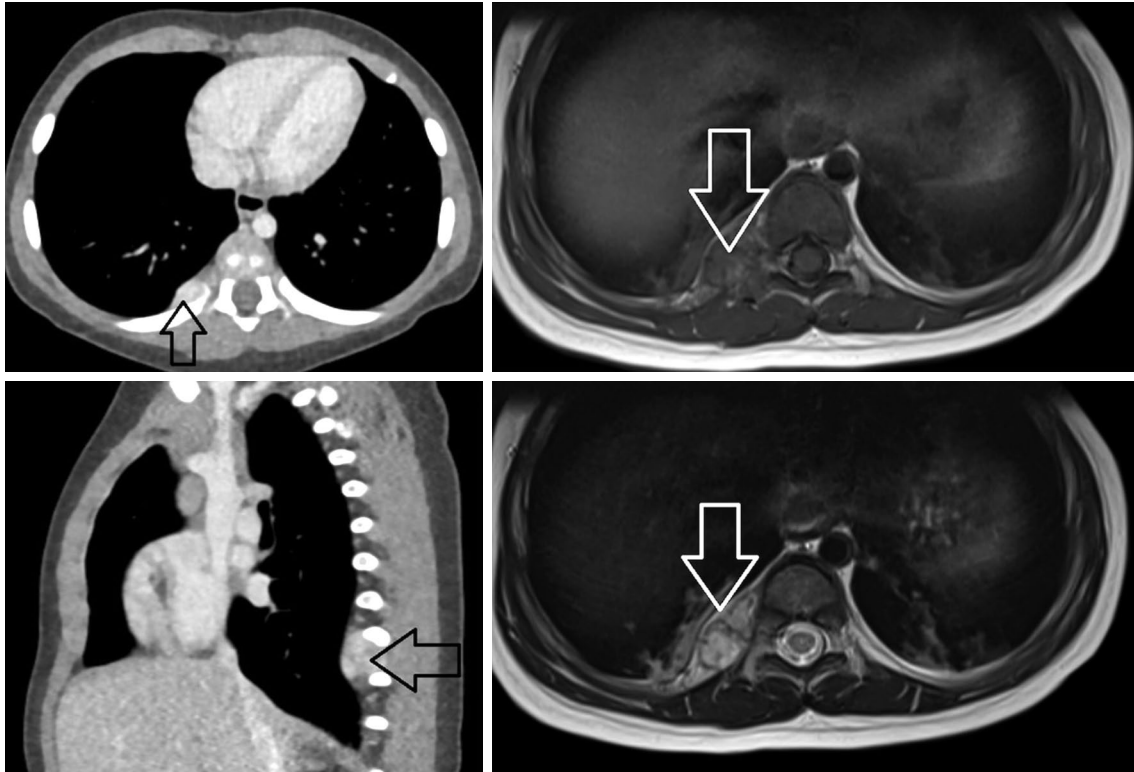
Preoperative computed tomography and magnetic resonance imaging of a one-year-old patient with a mediastinal mass.
